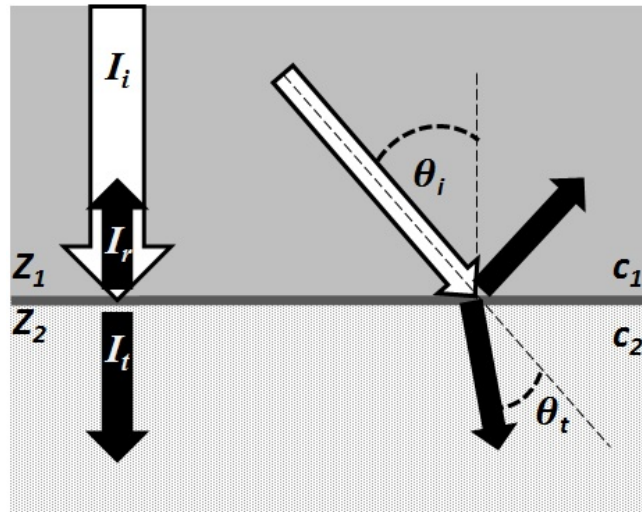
Incident ultrasound wave with intensity  $I_i$  is reflected at the boundary of materials with acoustic impedances of  $Z_1$  and  $Z_2$ , causing a portion to be reflected ( $I_r$ ) and transmitted ( $I_t$ ). Non-perpendicular incidence results in reflection away from the incident wave and refraction of the transmitted component.
